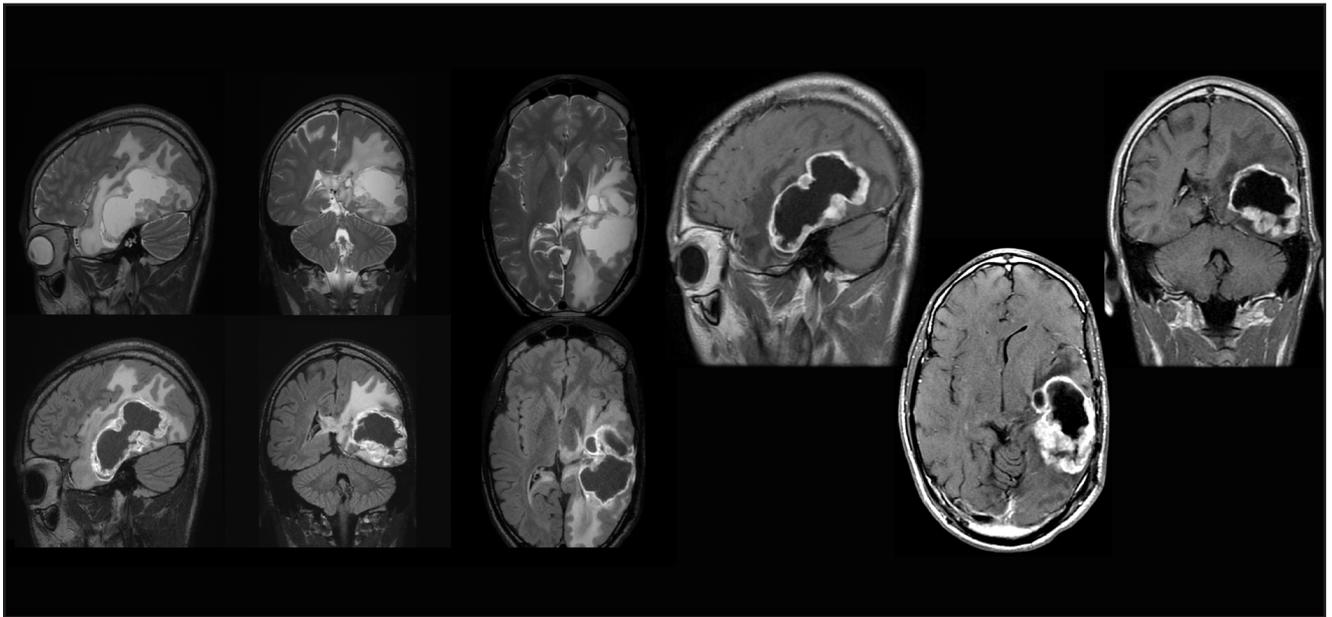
67-year-old patient with new-onset seizures. Volumetric T2-weighted imaging, and postcontrast FLAIR and volumetric T1-weighted imaging after administration of 15 mL Dotarem reveal a heterogeneously enhancing mass with significant surrounding high signal and associated mass effect consistent with a diagnosis of glioblastoma. Images courtesy of Dr. L. Tanenbaum.
